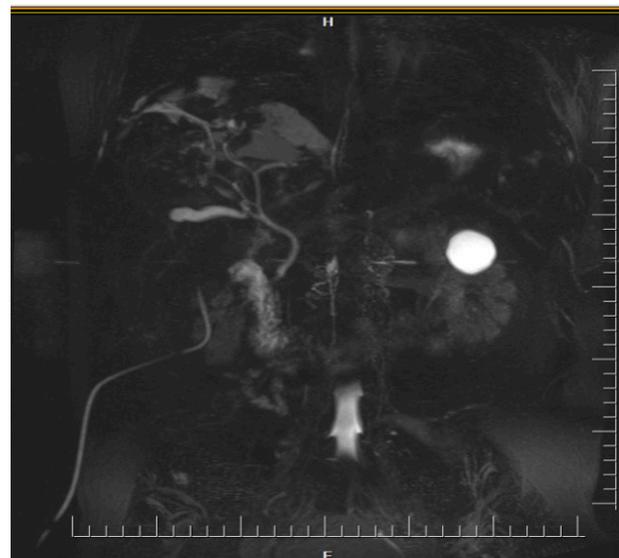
MRI of the patient after surgery
